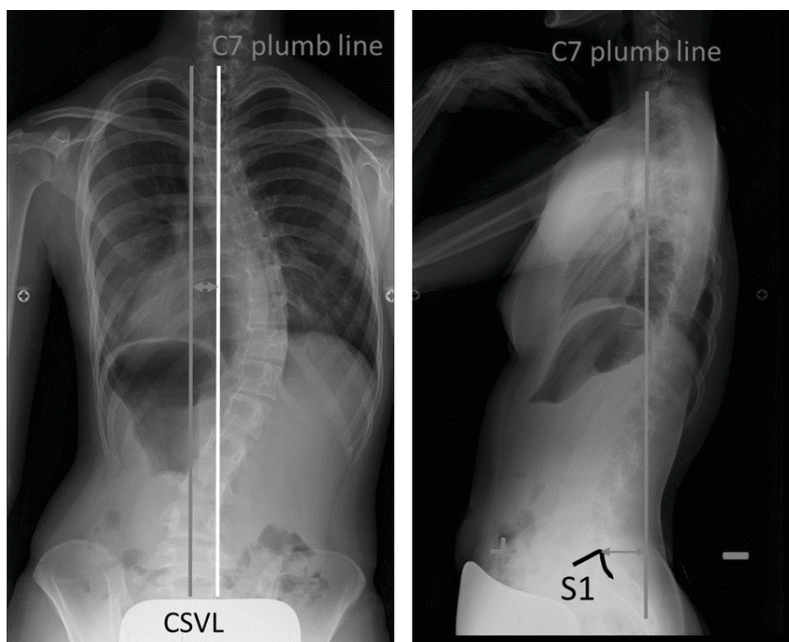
Coronal Vertebral Balance X-Ray analysis²⁰⁶
